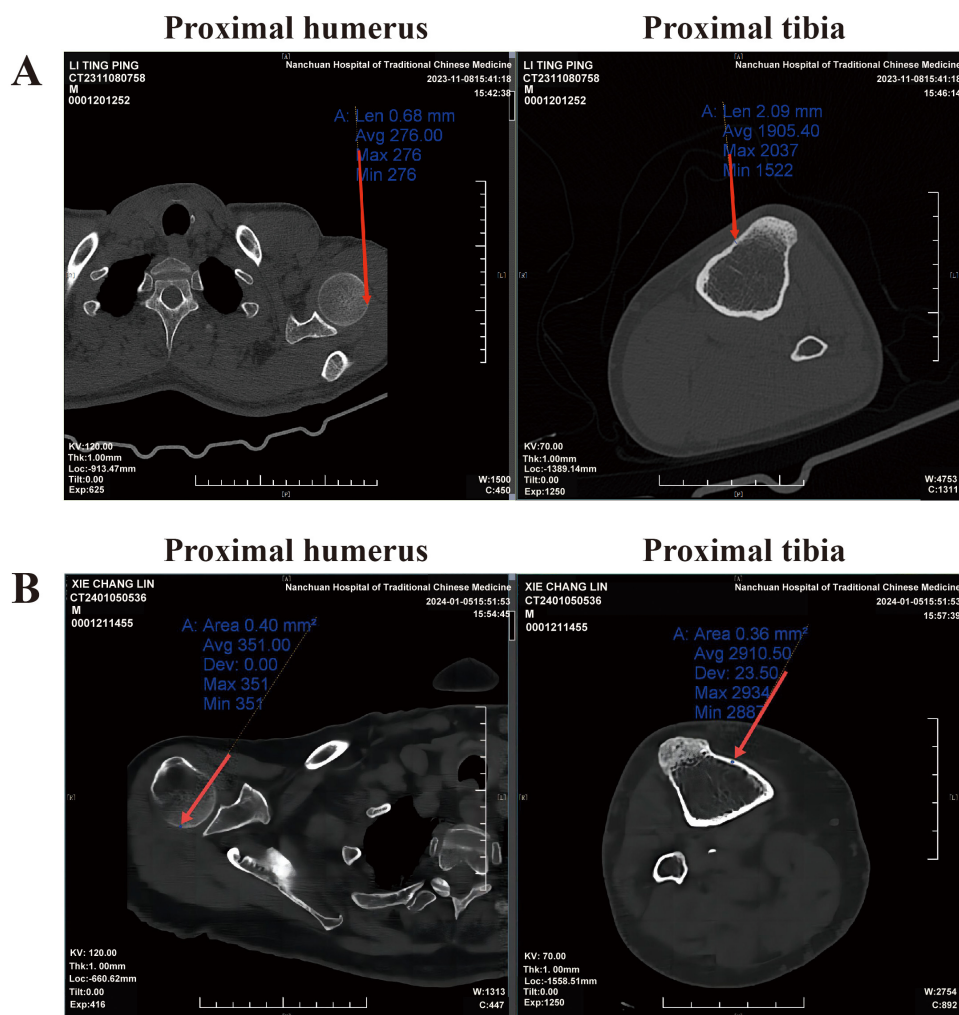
Representative computed tomography (CT) images. (A,B) Comparison of compact bone thickness and CT values between the proximal humerus and the proximal tibia in two representative cases. The red arrows indicate the specific position to be observed on the proximal humerus and proximal tibia.
